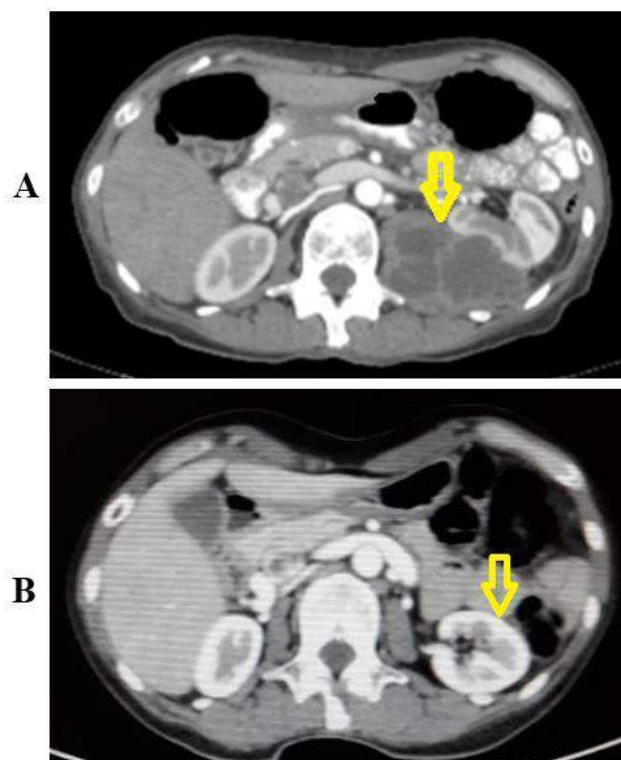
(A) Computed Tomography demonstrates left renal pseudotumor cysts before drainage. (B) Normal Computed Tomography after cysts drainage.
